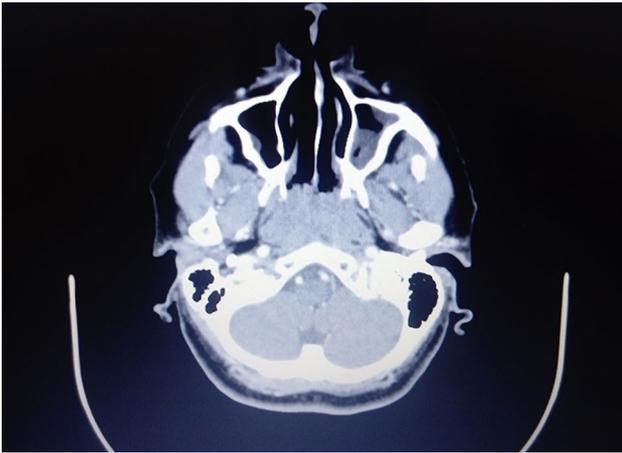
Case 1. Axial CT image of the diffusely enlarged postnasal space mass
